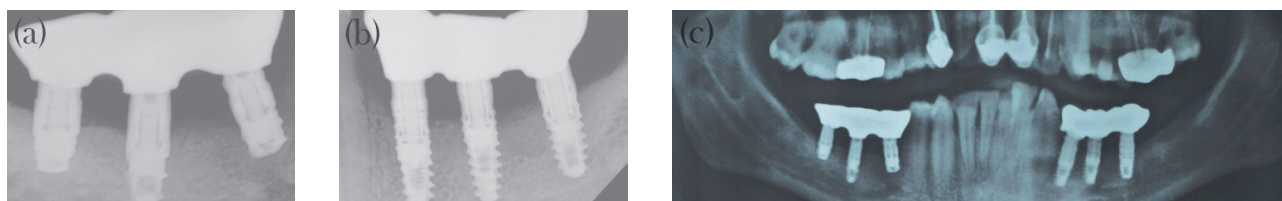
Radiographs of prostheses at 6 months.
